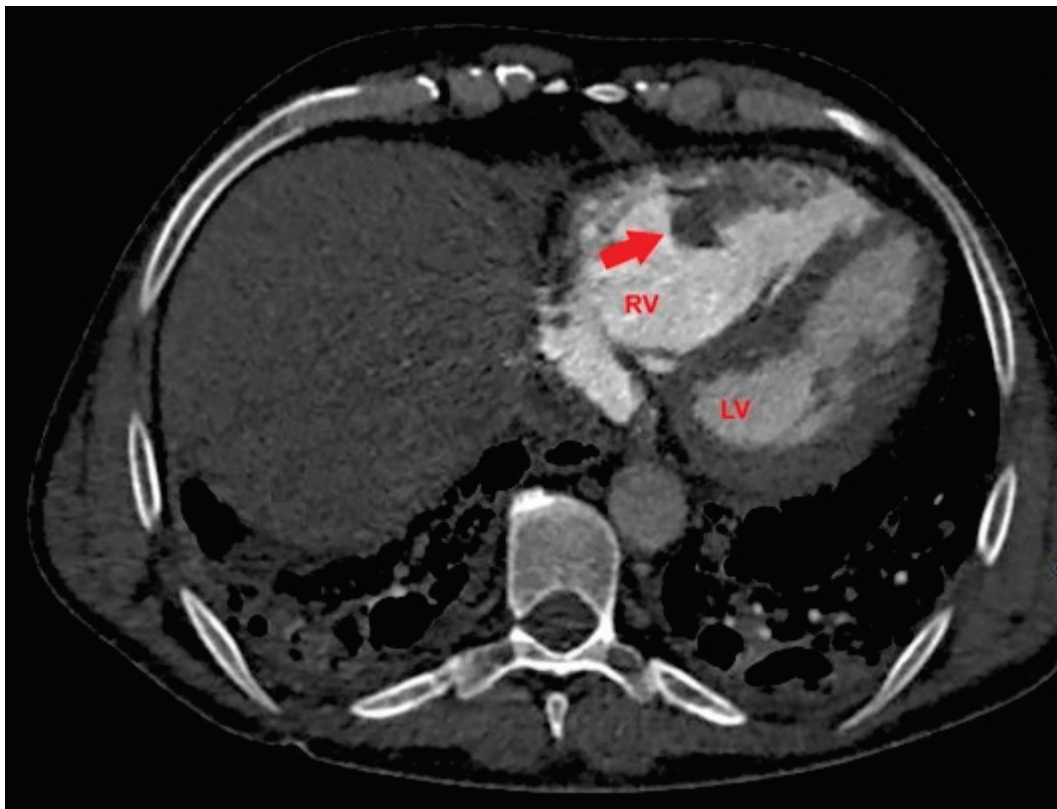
Axial contrast-enhanced chest computed tomography showing a large filling defect (red arrow) involving the mid-apical region of the right ventricle. LV, left ventricle; RV, right ventricle.
